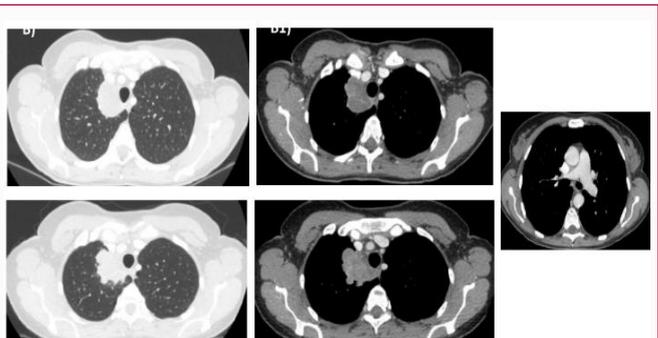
Chest computed tomography showing the lung mass on the right upper lobe. A) Mass with 43 mm × 33 mm at diagnosis and A1) In the mediastinal window, close mass contact with mediastinum and subclavian artery, without invasion. B) Progression of mass (65 mm × 49 mm) after two cycles of ChT. B1). In the mediastinal window, close contact with mediastinum, esophagus and vessels. B2) No mediastinal or hilar lymphadenopathy.
